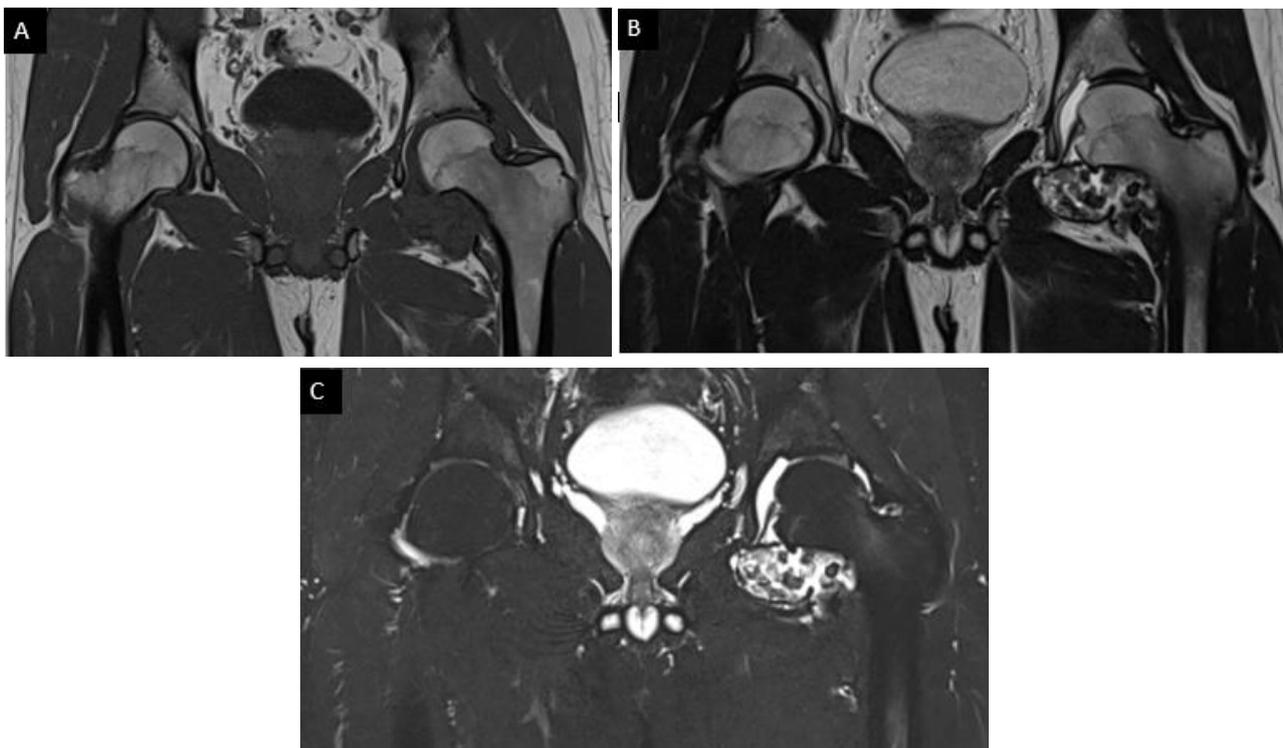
Coronal T1-weighted (A) and coronal T2-weighted (B) and coronal T2 fat-saturated (C) images of the left hip from an MRI demonstrating numerous similar-sized intra-articular loose bodies of variable signal intensity, some of them are showing intermediate to high signal intensity that is of cartilage. Others have low signal intensity at the periphery, which represents ossification. The joint capsule is distended with a little fluid and these numerous loose bodies. No significant degenerative changes of the joint
